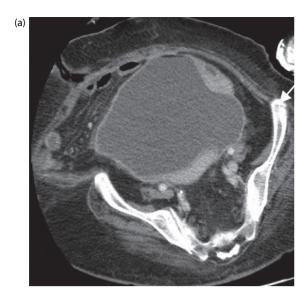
(a) Axial CT slice at the sacrococygeal level shows a prerectal abscess collection (arrow). (b) Axial CT slice at the same level as in (a) shows a drain *in situ* with significant abscess resolution.
